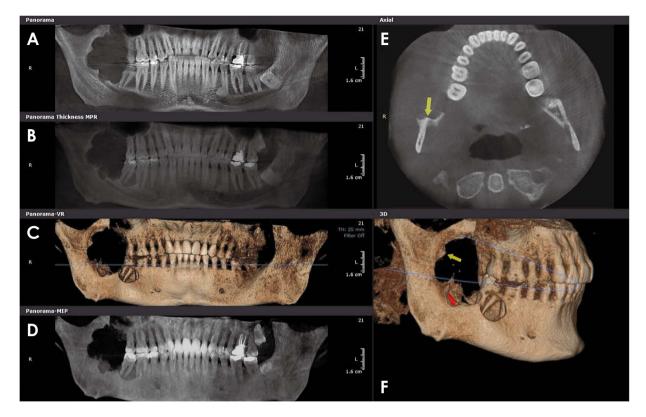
Scalloped borders of ameloblastoma in the posterior mandible on cone-beam computed tomographic images. A. Low-thickness multiplanar reformatted (MPR) image. The superior border of the inferior alveolar nerve canal cannot be clearly detected adjacent to the lesion. B. High-thickness MPR image. C. Three-dimensional volumetric image. D. Maximum intensity projection (MIP) panorama image shows extensive destruction along the anterior border of right mandibular ramus E. A scalloped border of the lesion (arrow) is seen in an axial image. F. Three-dimensional surface rendering image shows septation (arrow) between adjacent locules and destruction of the superior border of the inferior alveolar canal is also observed.
